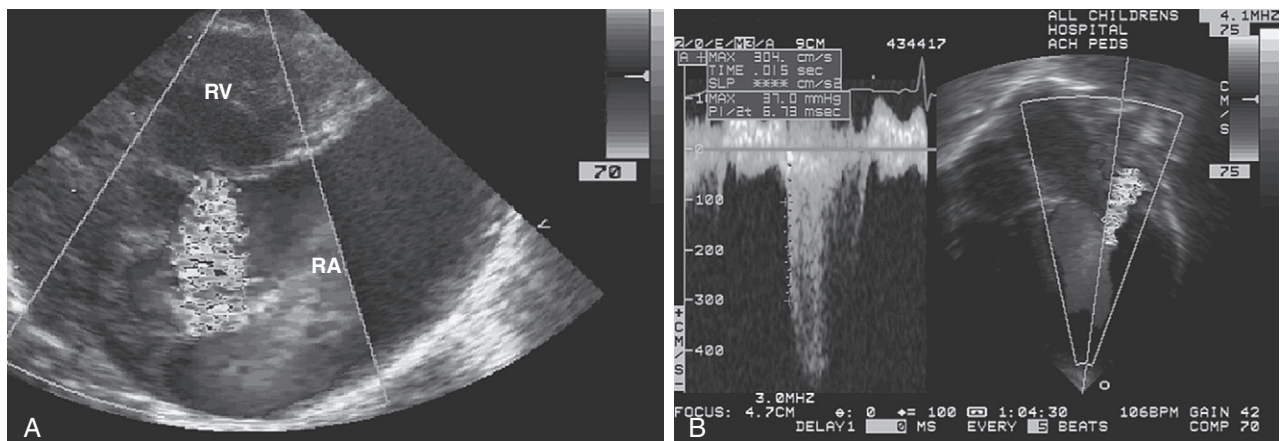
A, Tricuspid valve regurgitation in a neonate with pulmonary atresia with intact septum. Note enlargement of the right atrium (RA). RV, Right ventricle. B, Continuous-wave Doppler shows a very high predicted pressure in the hypoplastic right ventricle.
